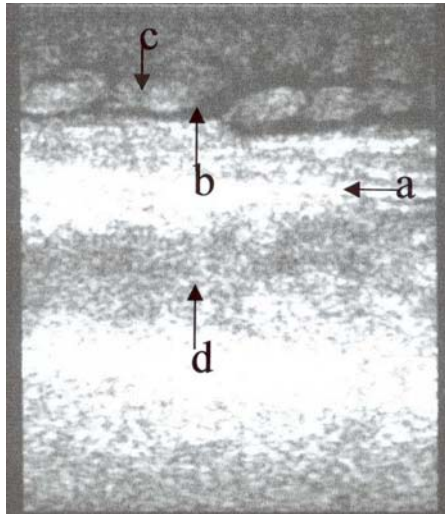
The gray scale ultrasonogram of legs lymphedema
